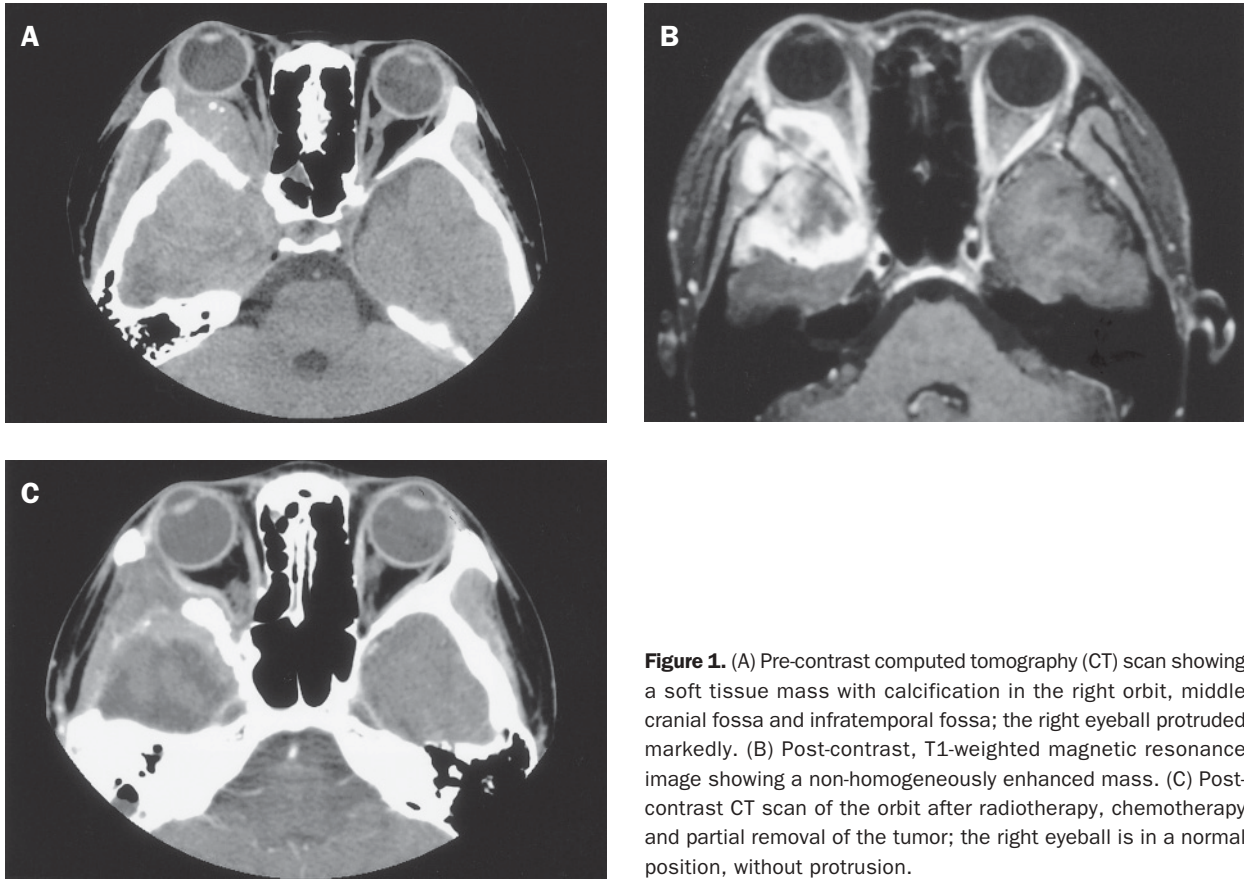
(A) Pre-contrast computed tomography (CT) scan showing a soft tissue mass with calcification in the right orbit, middle cranial fossa and infratemporal fossa; the right eyeball protruded markedly. (B) Post-contrast, T1-weighted magnetic resonance image showing a non-homogeneously enhanced mass. (C) Post-contrast CT scan of the orbit after radiotherapy, chemotherapy and partial removal of the tumor; the right eyeball is in a normal position, without protrusion.
